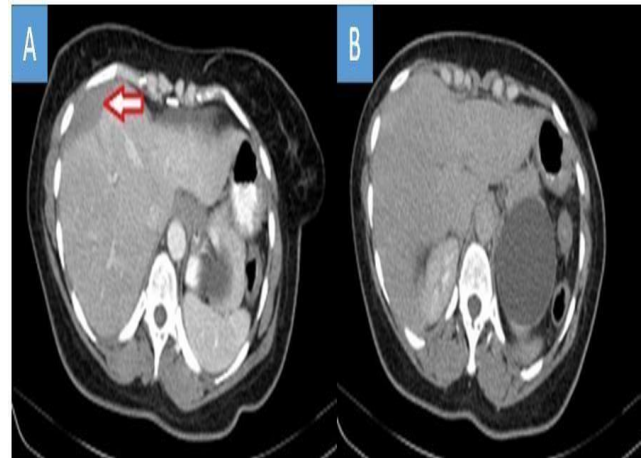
(A and B): Abdominal CT imaging, arrow showing liver hematoma following administration of tamoxifen. Resolution of the hematoma after the cessation of tamoxifen therapy.
